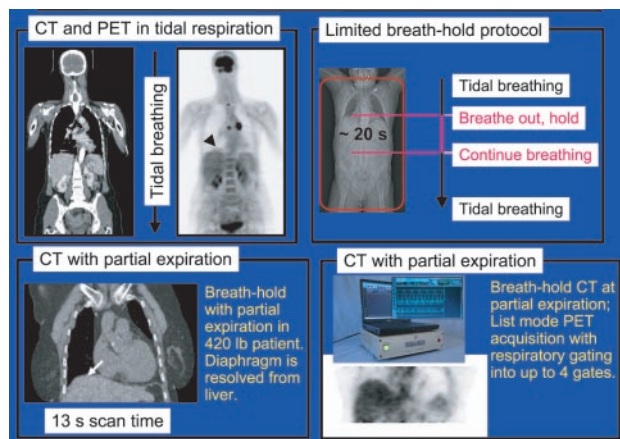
Respiratory gating with a 16-slice LSO PET/CT scanner. The separation of the heart from the liver can be delineated to indicate partial respiration (lower left).
